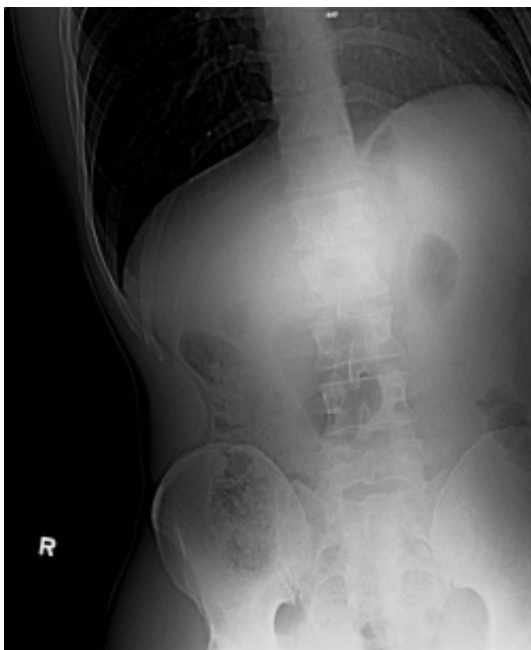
Left lateral decubitus abdominal X-ray showing medial displacement of the gastric bubble.
